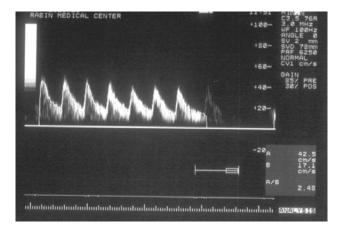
Doppler signals obtained from the umbilical artery of the normal twin. Note normal pulsatile pattern
